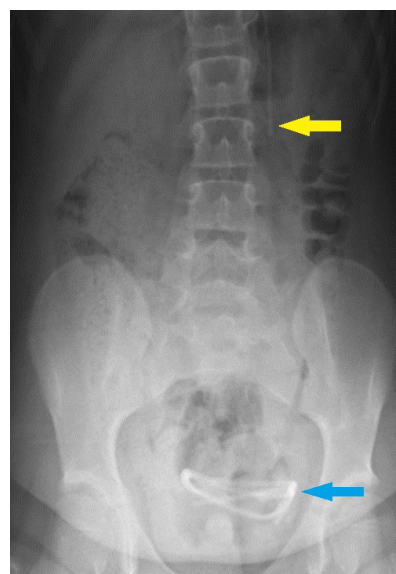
Abdominal radiography ventriculoperitoneal shunt fracture at L3 vertebrae level (yellow arrow) and presence of shunt fragment in the small pelvis (blue arrow).
